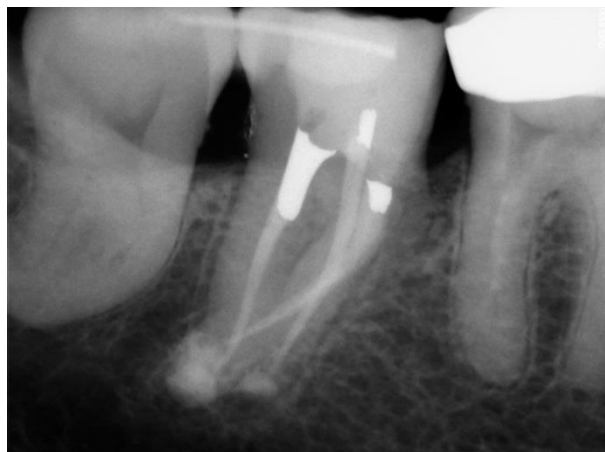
Intraoperative endoral X-ray.
